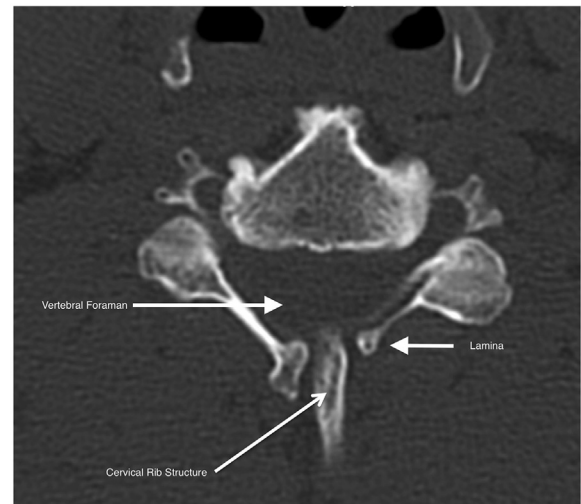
Axial CT images noting the midline anomalous rib entering the spinal canal.
